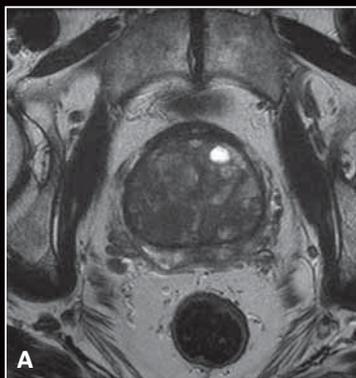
Comparison of diffusion techniques in the body. (A) Axial T2 PROPELLER (B) Standard EPI-DWI technique. (C) Using FOCUS DWI, there is an improvement in resolution compared to the standard EPI-DWI technique. (D) MUSE DWI further improves resolution and minimizes distortion. All scans were acquired with b800 and AIR Technology™.
